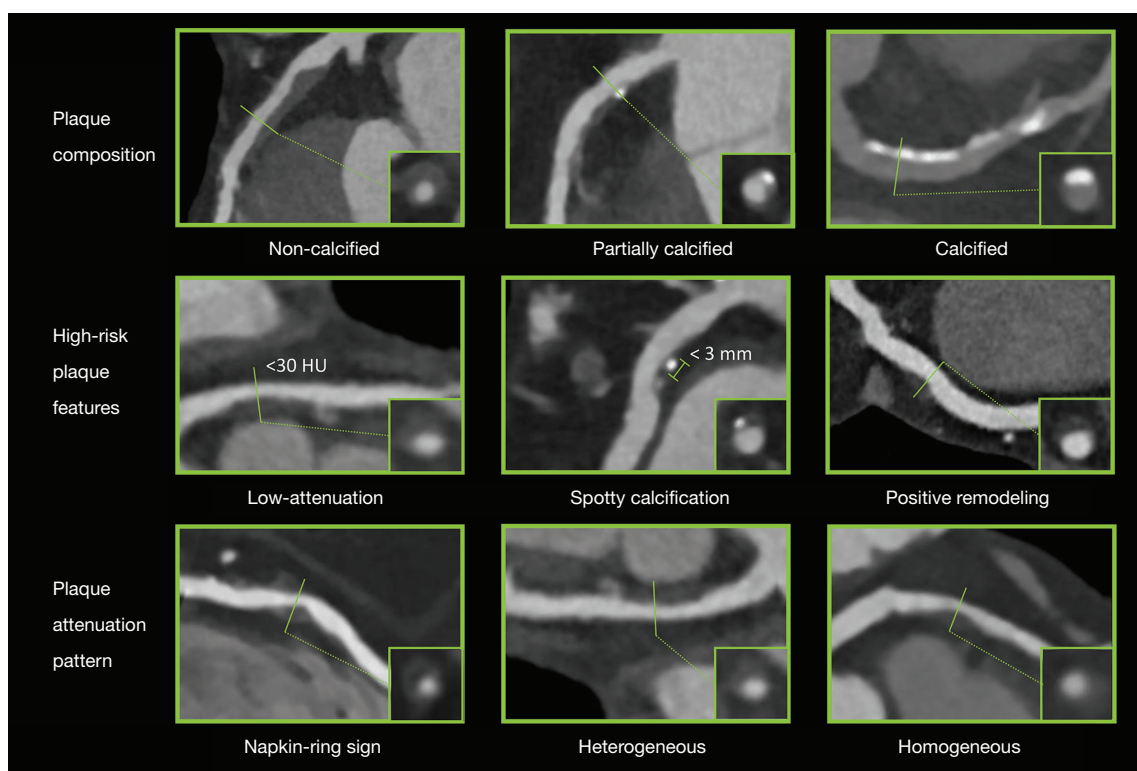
Representative images of plaque characteristics identifiable using coronary CT angiography (CTA).
